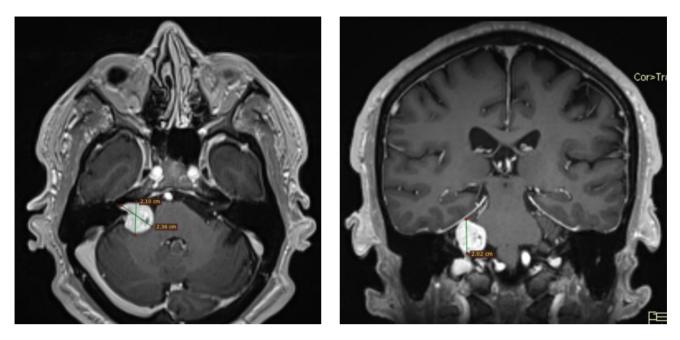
Brain MRI shows an internal auditory canal and a CPA tumor on the right side.
